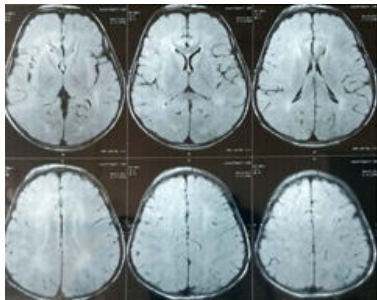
MRI FLAIR showing multifocal white matter hyperintensities
